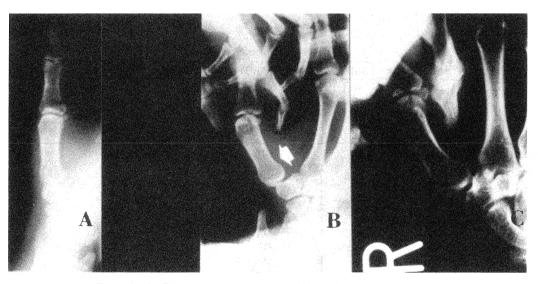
A: Plain roentgenogram revealed no abnormality and kept stage 1.
